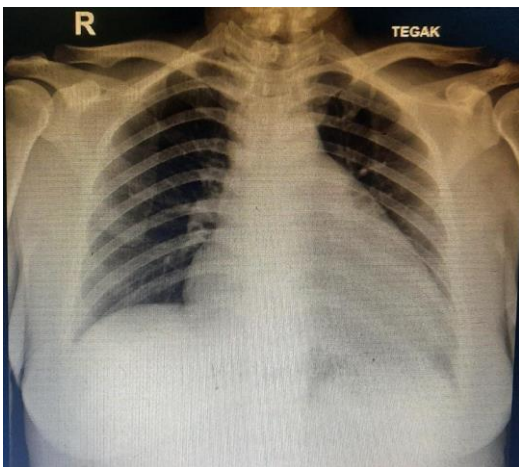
X-Ray showed cardiomegaly
